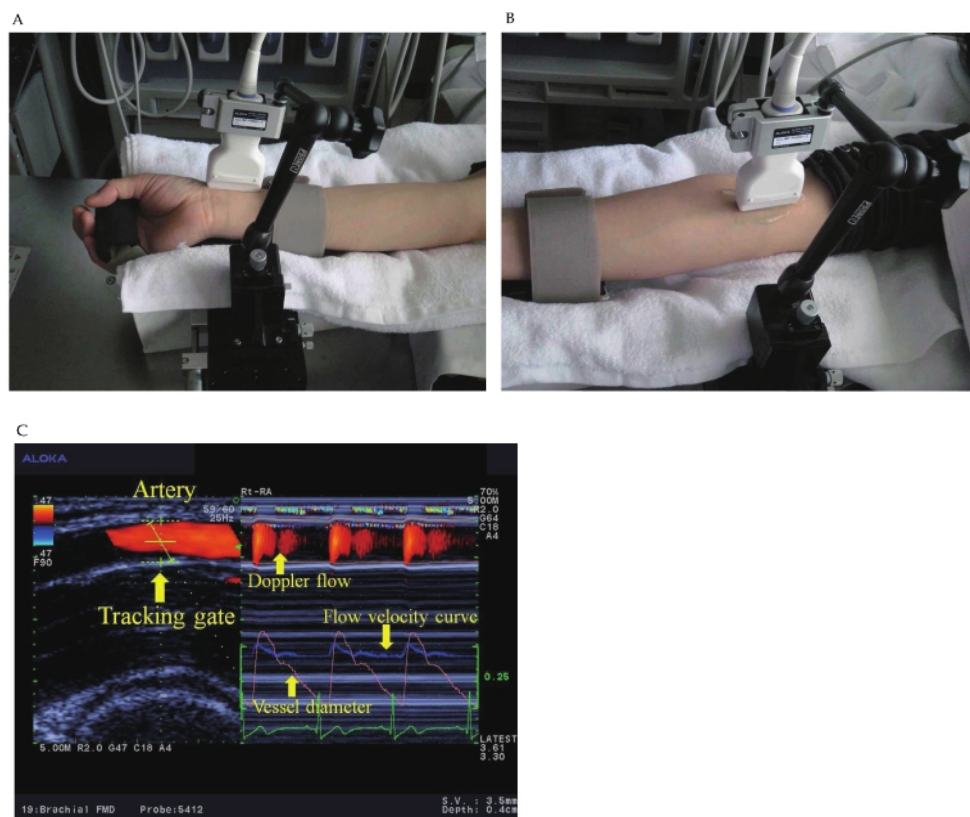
(A) Ultrasound measurement of the radial artery with a special probe holder. (B) Brachial artery measurement. (C) Left, the vessel image and the position of the tracking gate of the artery; Right, the changes in the vessel diameter, Doppler flow, and flow velocity determined using an automated edge detection device and computer analysis software (e-Tracking system ®, Aloka Co., Ltd., Tokyo, Japan).
